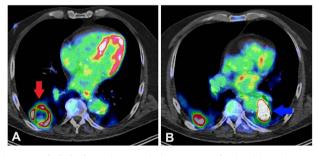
Whole body positron emission tomography (PET) imaging showing 4.6×4.6 cm right lower lobe spiculated mass with max standard uptake value (SUV) of 7.1 and central necrosis (panel A, arrow). On the left lobe, there is a 4.8×2.7 cm spiculated mass with max SUV of 17.6 that abuts the descending thoracic aorta (panel B, arrow). Of note, there is no increased lymph node or gastrointestinal avidity reported in this study.
